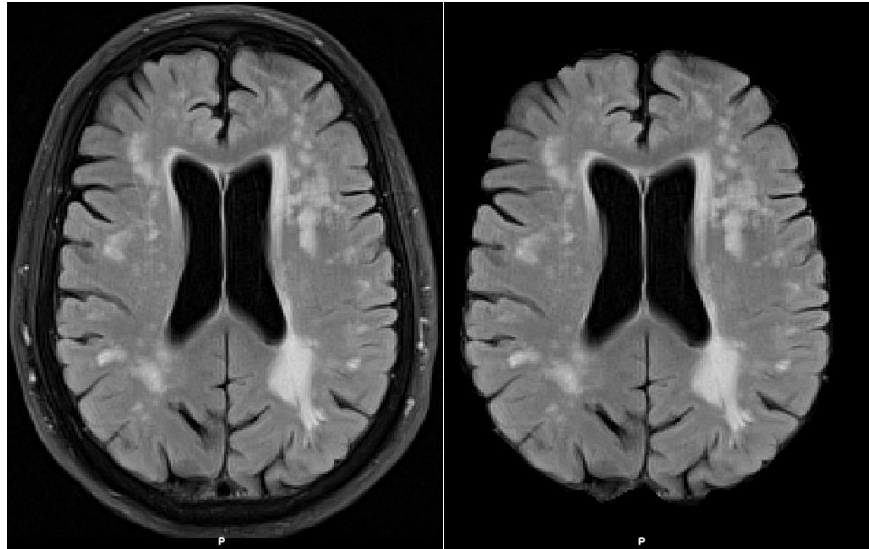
Original (left panel) and brain-extracted (right panel) FLAIR image.
